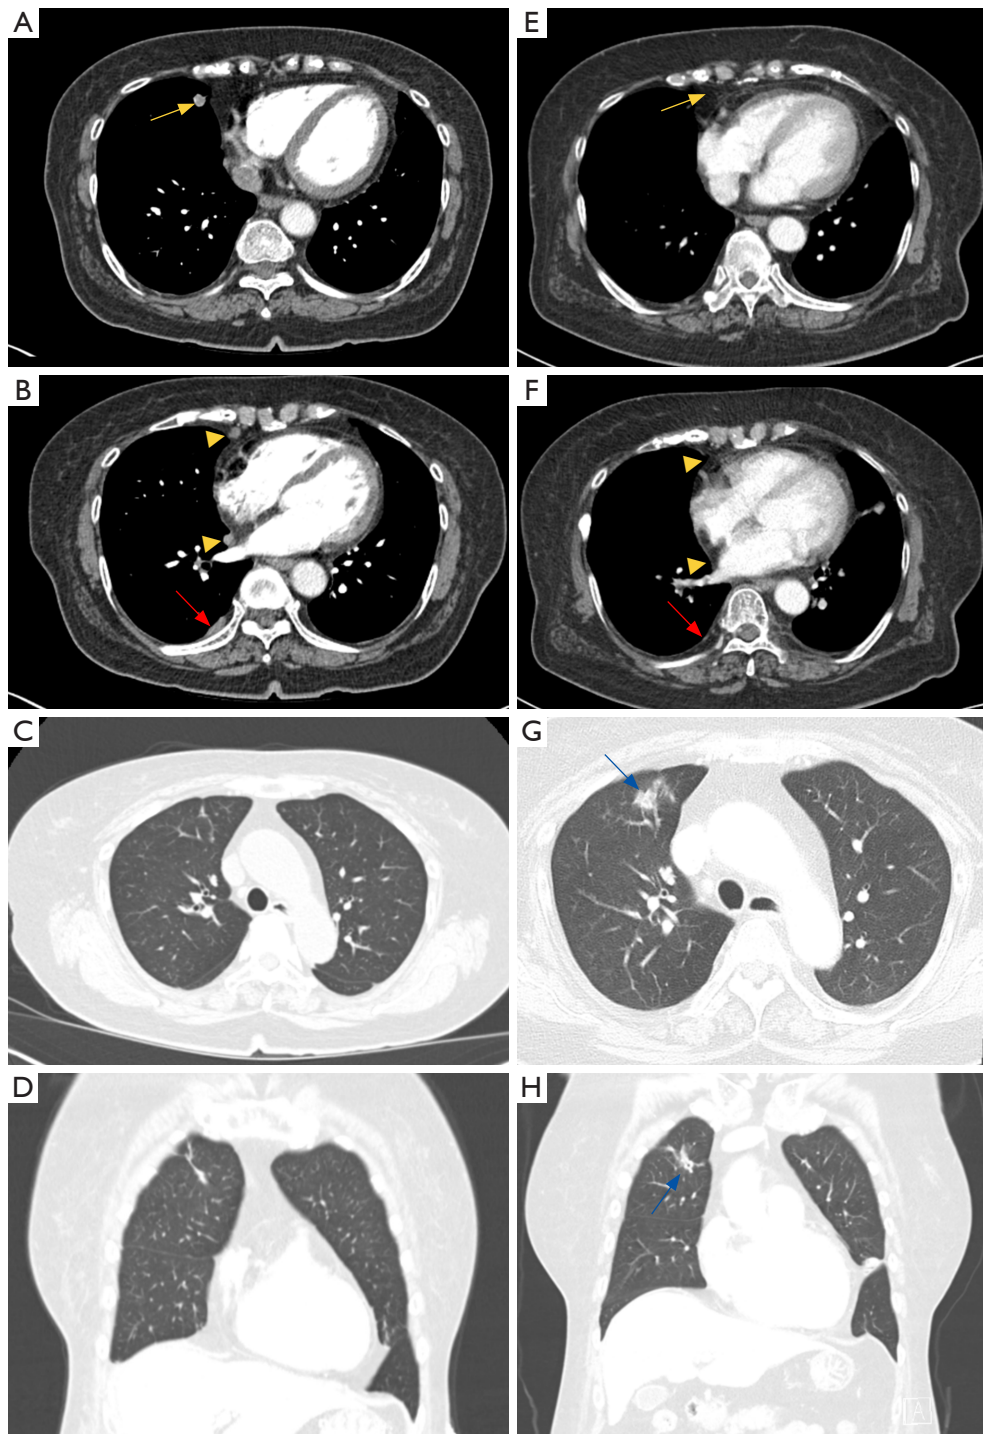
Chest CT images at initial in November 2022 and before 2nd biopsy in July 2024. (A,B) Initial CT for main nodule in RML (yellow arrow), multiple other nodules (yellow arrowheads) and pleural thickening (red arrow). (C,D) Initial CT for lung fibrosis in RUL. (E,F) CT in July 2024 showing resolution of RML nodule (yellow arrow), multiple other nodules (yellow arrowheads) and pleural thickening (red arrow). (G,H) CT in July 2024 showing newly appeared consolidation with ground-glass opacity in RUL (blue arrow). CT, computed tomography; RML, right middle lobe; RUL, right upper lobe.
